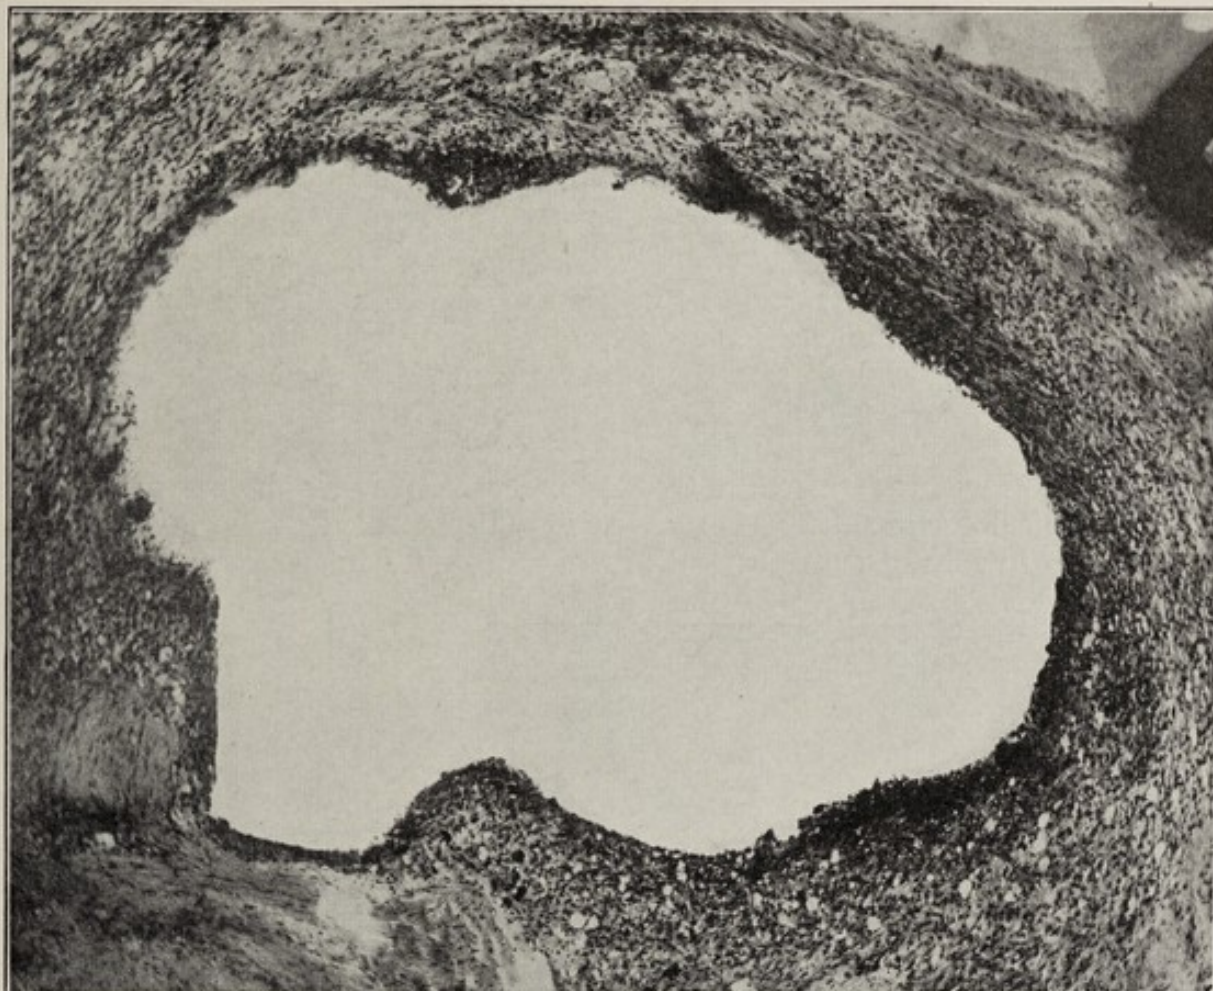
Chronic periapical abscess. Most of the cavity is lined with epithelial cells. There is a well defined fibrous tissue capsule.
